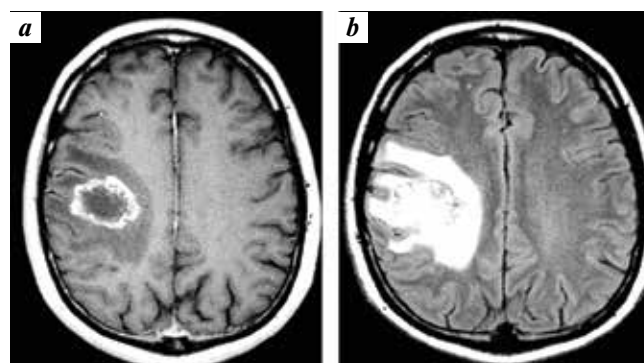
Preoperative (17.03.2014) MRI tomograms (axial scans, contrast enhancement) of patient H. with an intracerebral tumor of the right frontoparietal region with a cystic component: a – T1 mode with contrast; b – T2 FLAIR mode
